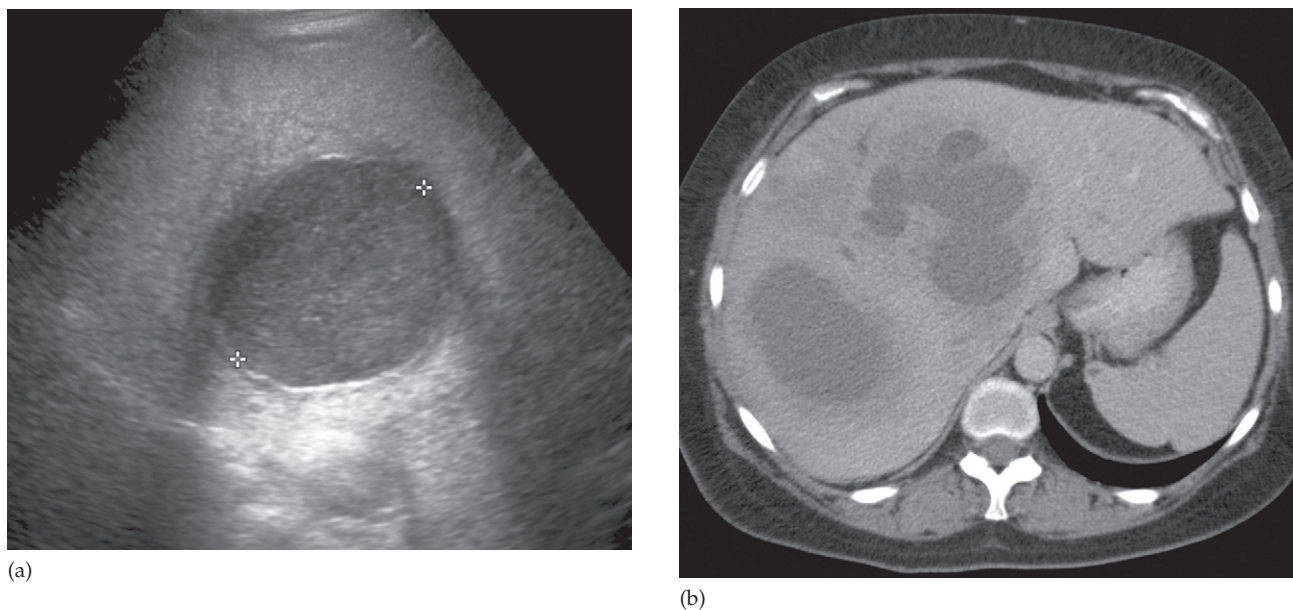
Liver abscess. (a) Ultrasound scan showing an area of mixed echogenicity in the liver. (b) CT in another patient showing multifocal areas of low attenuation. Compared to liver cysts (see Fig. 7.15a), they are not nearly as well circumscribed.
